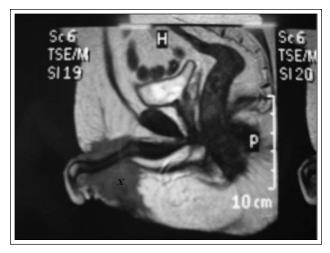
The magnetic resonance imaging scan showing the metastatic penile mass (asterix).
